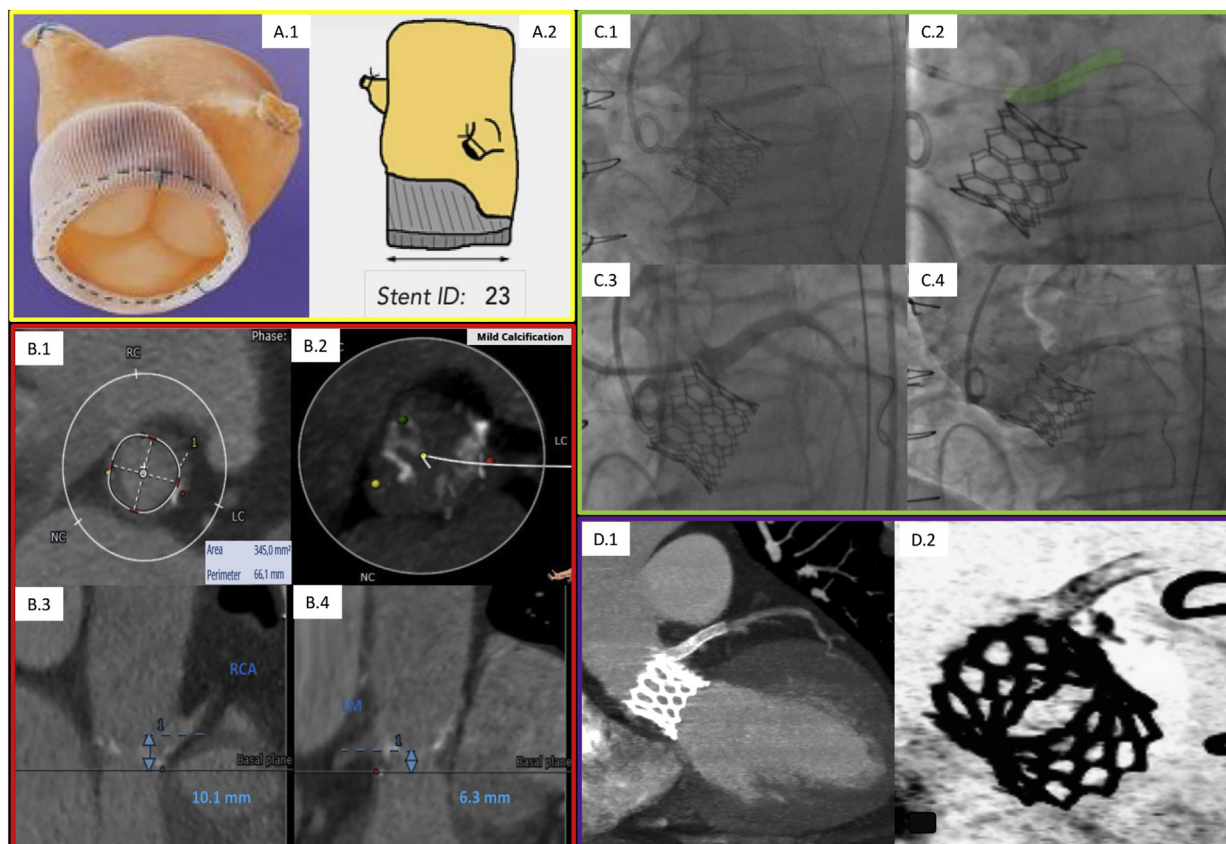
(A) Stent-less Toronto SPV aortic root bioprosthesis. (B) Degenerated stentless bioprosthesis (1–2) and the low (6.3 mm) left main-to-Dacron/annulus height (3–4) at pre-procedural MSCT. (C) Left main stent implantation with protrusion in the aortic root lumen over the transcatheter heart valve upper edge (1–2). Immediate final angiographic result (3–4) and (D) 6-month MSCT follow-up. MSCT: multi-slice computed tomography.
